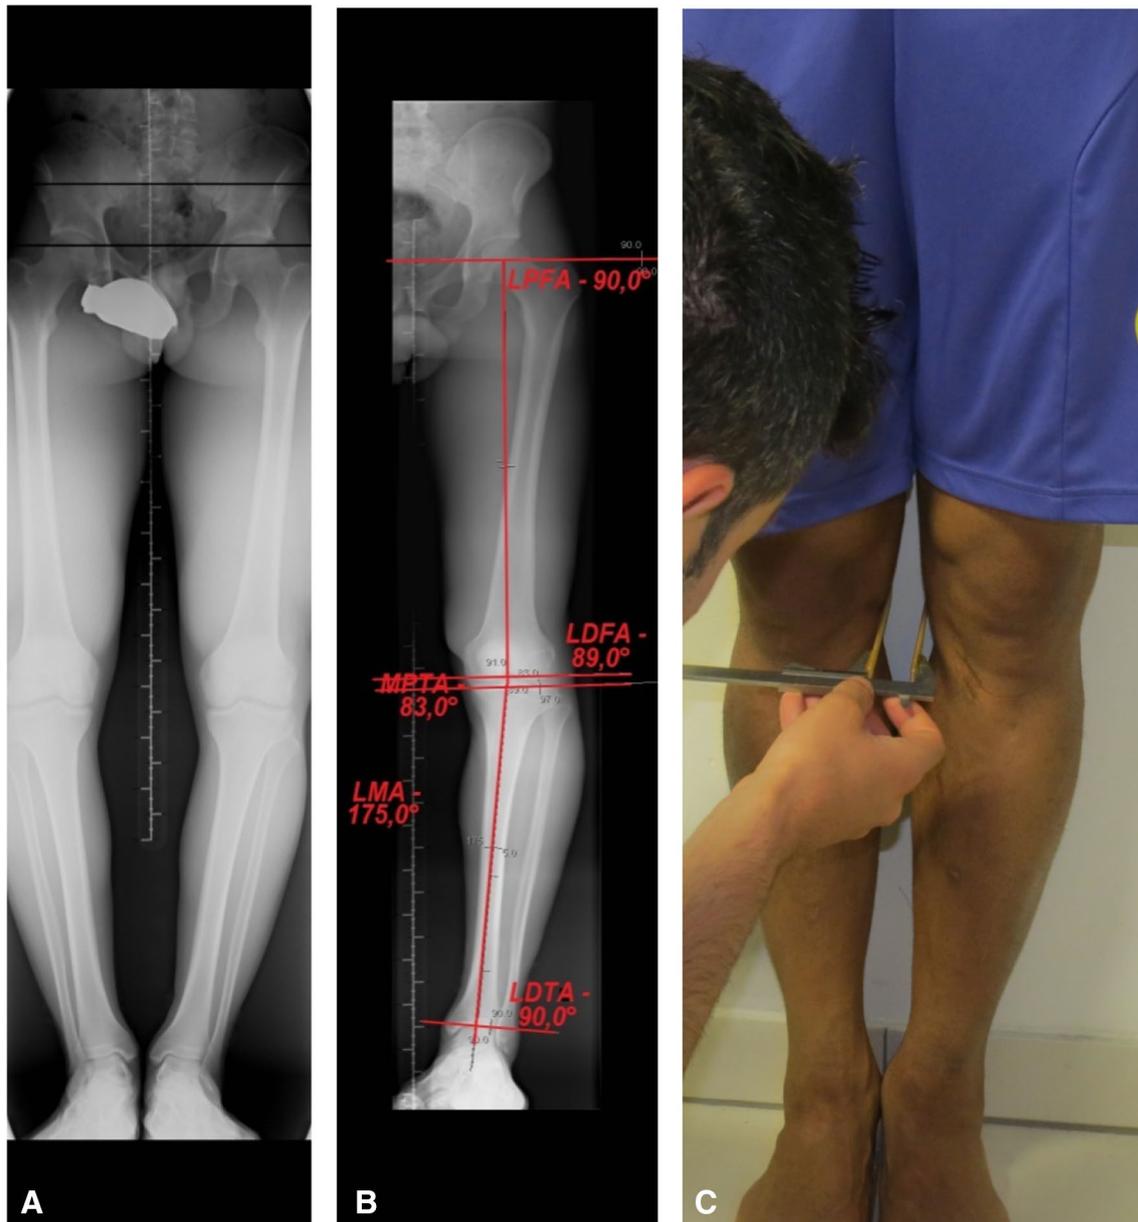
Bilateral full-leg weight bearing radiograph of a football player (a) with radiographic analysis of axis and lower limb mechanical angles (b), and an example of the ICD/IMD clinical measurement with a caliper (c)
